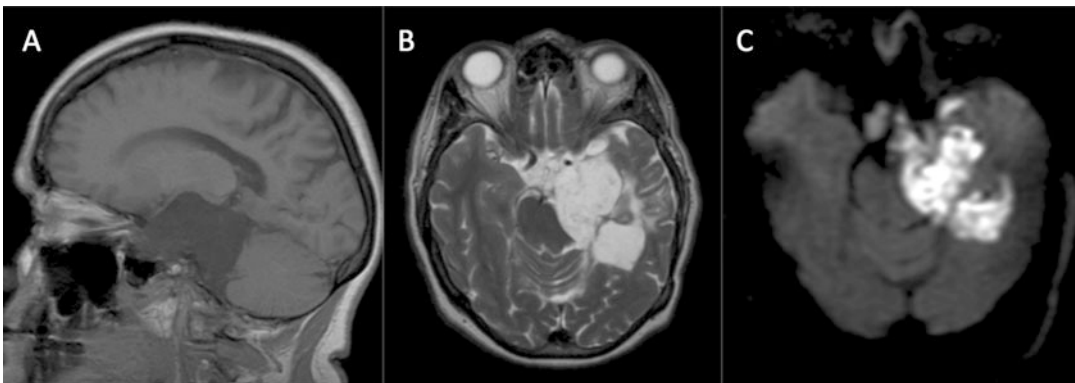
Epidermoid cyst. T1w (a), T2w (b), and b1000 DWI (c) images highlighting typical features of an extra-axial, in particular diffusion restriction (ADC map not provided)
